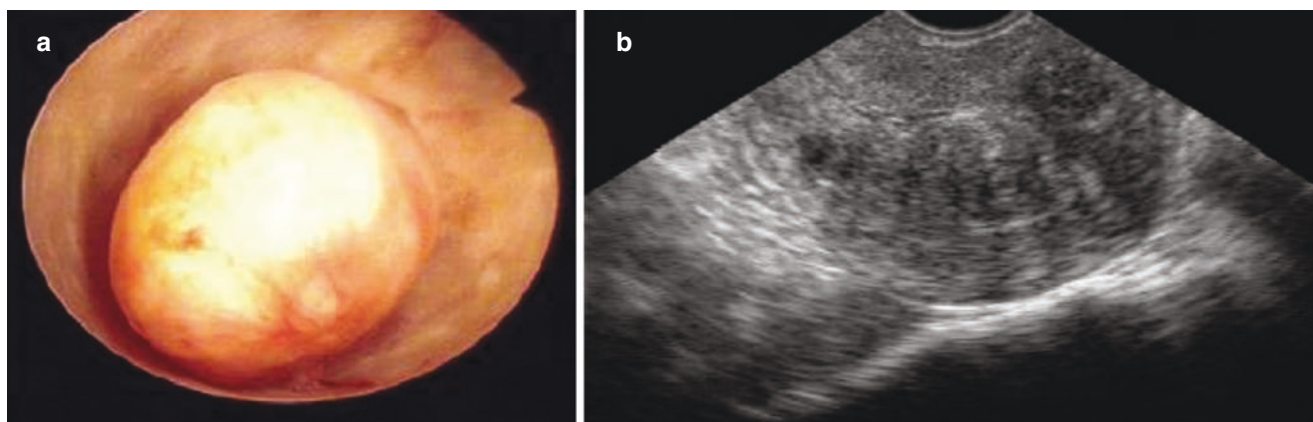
Submucous myoma. (a) Hysteroscopy shows the submucous myoma. (b) Ultrasonography shows the submucous myoma
